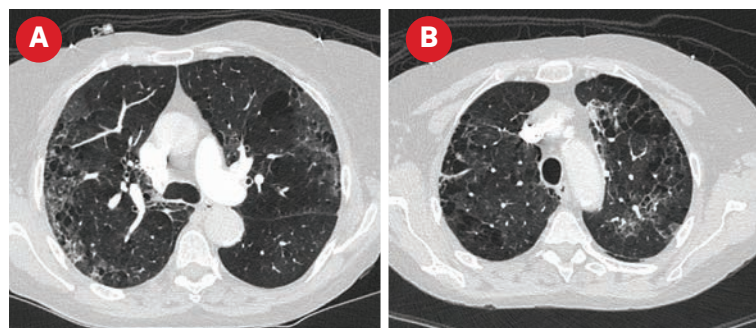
Serial non-contrast CT scans with transaxial slices. Figures 4A and 4B. Initial CT scan with peripheral ground glass opacities of COVID-19 pneumonia.
